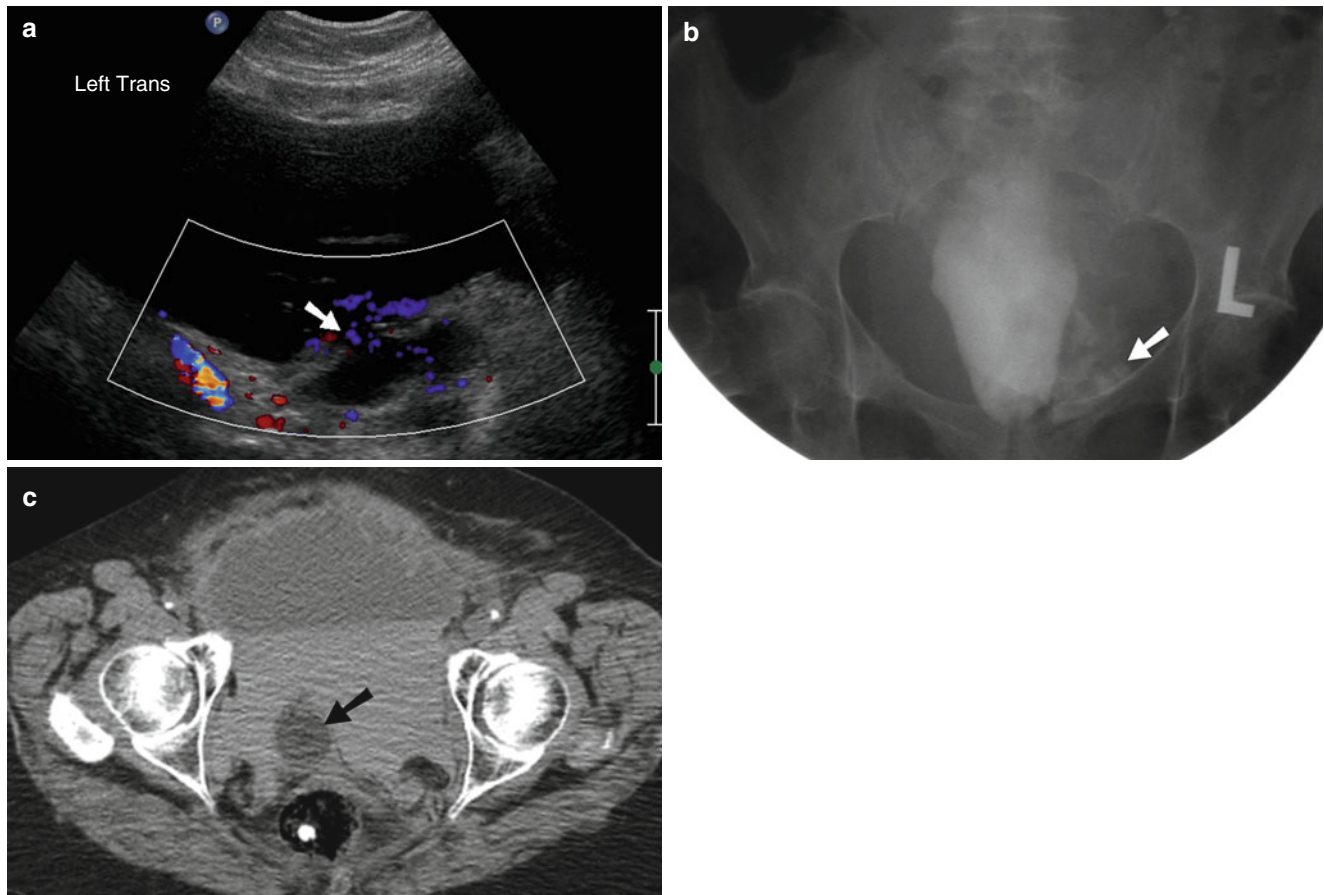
Urinary bladder rupture. (a) Ultrasound image of the pelvis demonstrating direct transperitoneal communication (*arrow*) between urinary bladder and a large pelvic urinoma. (b) Cystogram study depicts
